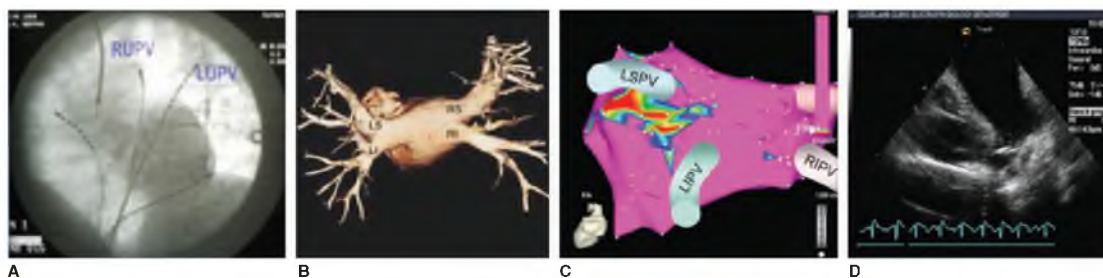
Overview of imaging modalities in common use for atrial fibrillation evaluation and ablation. The figure shows examples of fluoroscopy (A), computed tomography (B), electroanatomic mapping (C), and intracardiac echocardiography (D) as they are used for guiding ablation of atrial arrhythmias. LI, left inferior; LIPV, left inferior pulmonary vein; LS, left superior; LSPV, left superior pulmonary vein; LUPV, left upper pulmonary vein; RI, right inferior; RIPV, right inferior pulmonary vein; RS, right superior; RUPV, right upper pulmonary vein.
